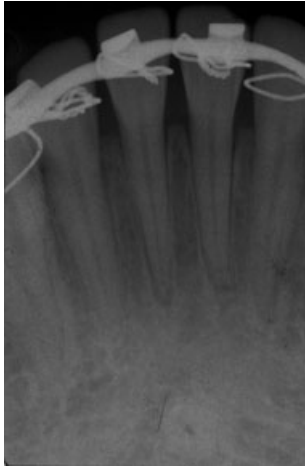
Radiograph taken at the emergency room after repositioning and splinting.
